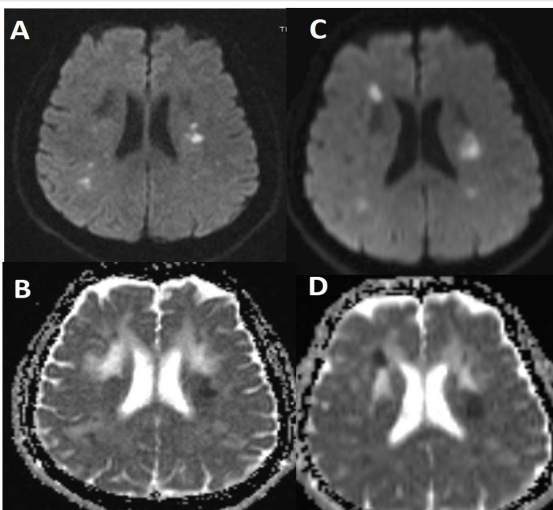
DWI-MRG at onset (A,B) and after clinical progression (C,D) the enlargement of ischemic lesion as well as appearance of new ischemic infarctions in bilateral border-zone areas
